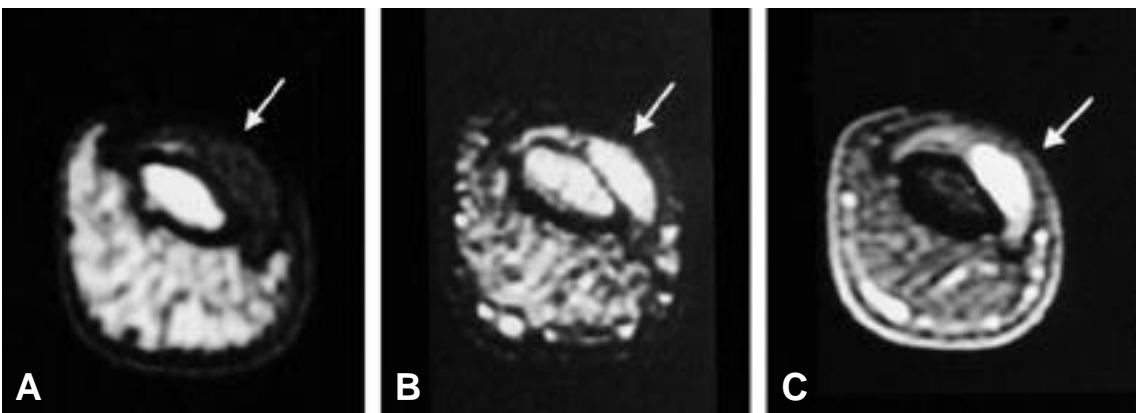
MRI showed low signal intensity on T1WI(A), high signal intensity on T2WI(B) and strong enhancement on Gadolinium enhanced T1WI of the left thumb(C)(case 6).
